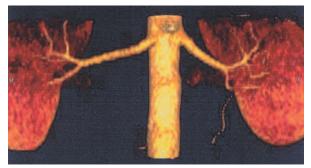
Normal renal arteries. 3D reformatted CT angiogram.
